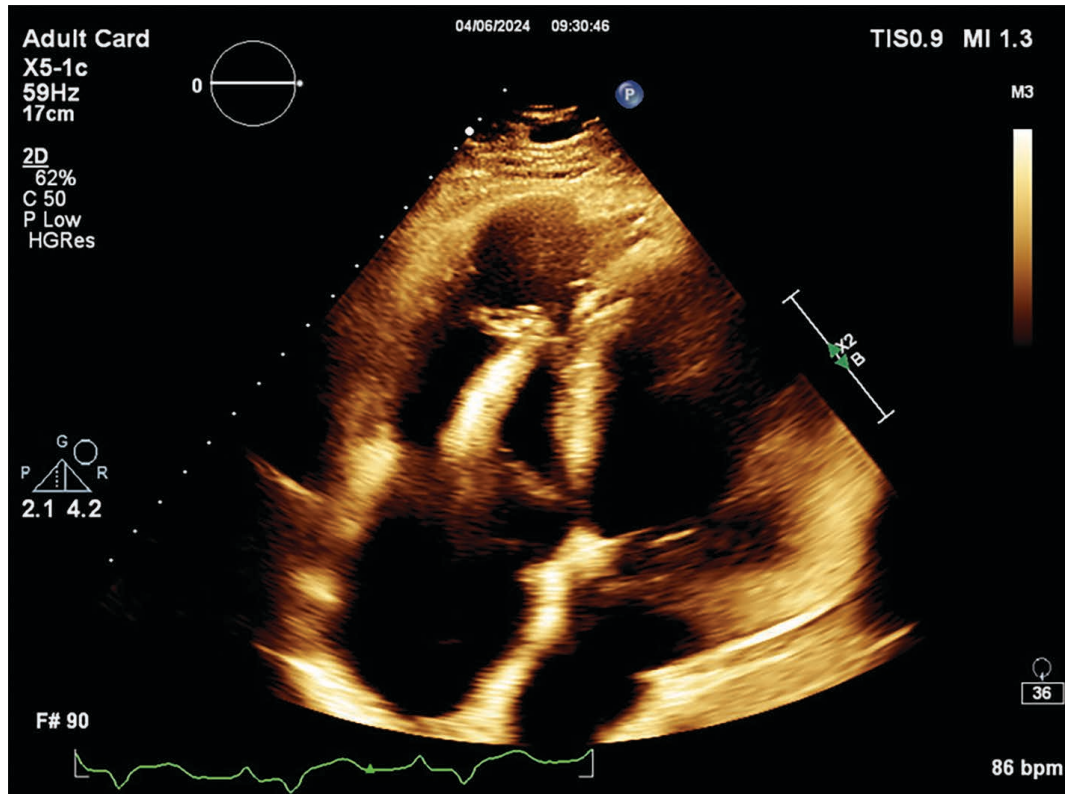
Apical 4-chamber view (2D) shows the dilated RV with an aneurysmal apex, and the ICD lead is visible.
